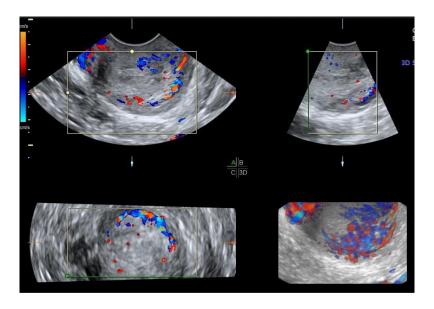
Transvaginal ultrasound. Cervical cancer, 2D imaging and color-flow.
